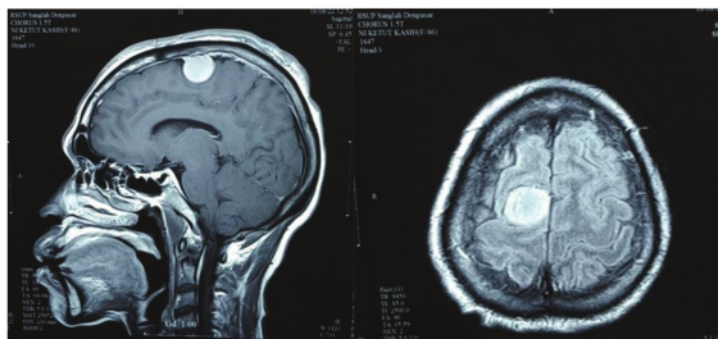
T2W1 FLAIR Head MRI
